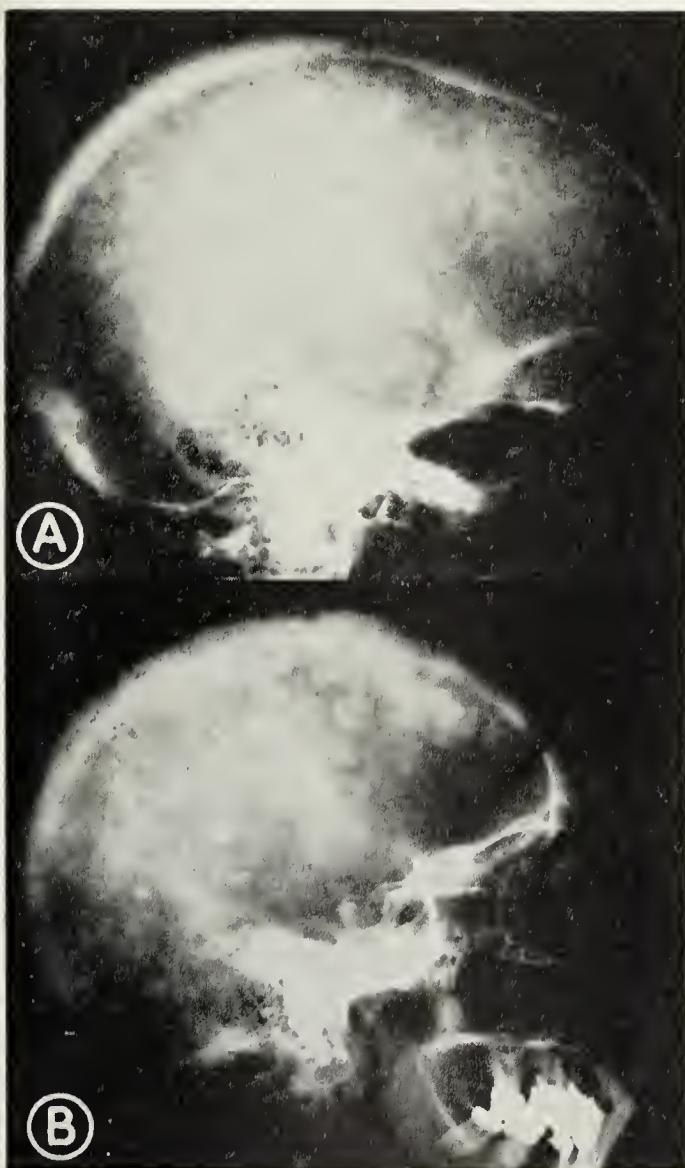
Photographs of x-ray films of skulls comparing osteitis fibrosa generalisata with Paget's disease of bone. (A) The thick "moth-eaten" skull of a patient with osteitis fibrosa generalisata. (B) The overgrown skull of a patient with Paget's disease. Note the area of destruction in the frontal region.
